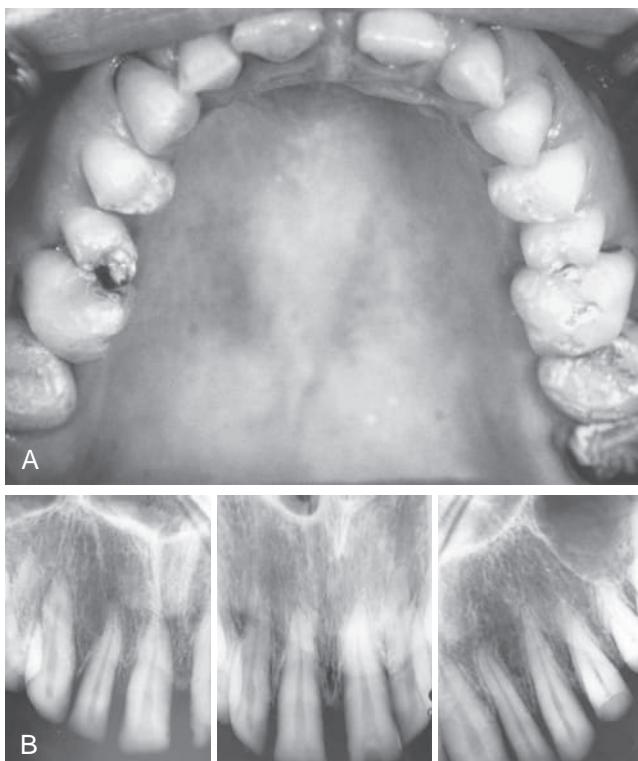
(A) Case diagnosed as amelogenesis imperfecta. The permanent teeth have a thin covering of pigmented enamel. (B) The radiographs show essentially normal root morphology. The crowns have a thin covering of enamel.
